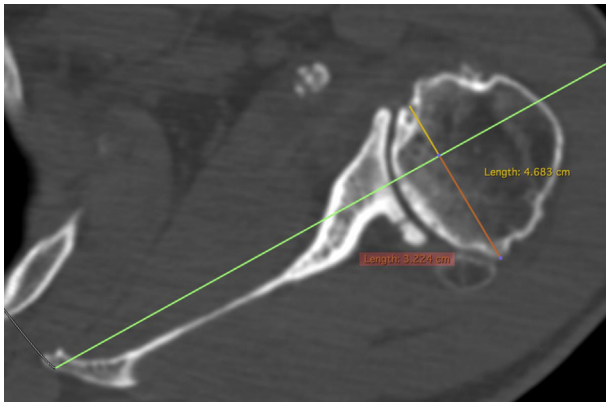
Representative shoulder axial computed tomography slice oriented in the plane of the scapula used for measurement of humeral head subluxation. The diameter (D) of the humeral head was measured, and the distance from the mid portion of the glenoid to the posterior aspect of the humeral head was measured (d). These numbers were then divided (d/D) and produced the percentage of posterior humeral head subluxation, with 50% noted to be a well-centered head with no significant posterior subluxation.
